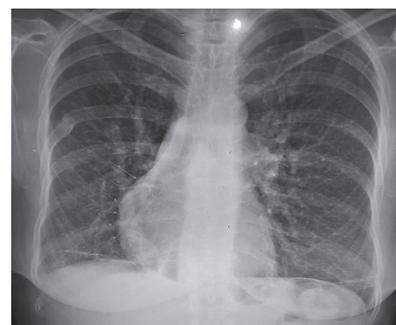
Curvilinear pattern created in the chest radiograph by the right pulmonary vein that drains to the inferior vena cava. This radiographic density often has the shape of a scimitar (scimitar sign, red arrows), a type of curved blade sword.
